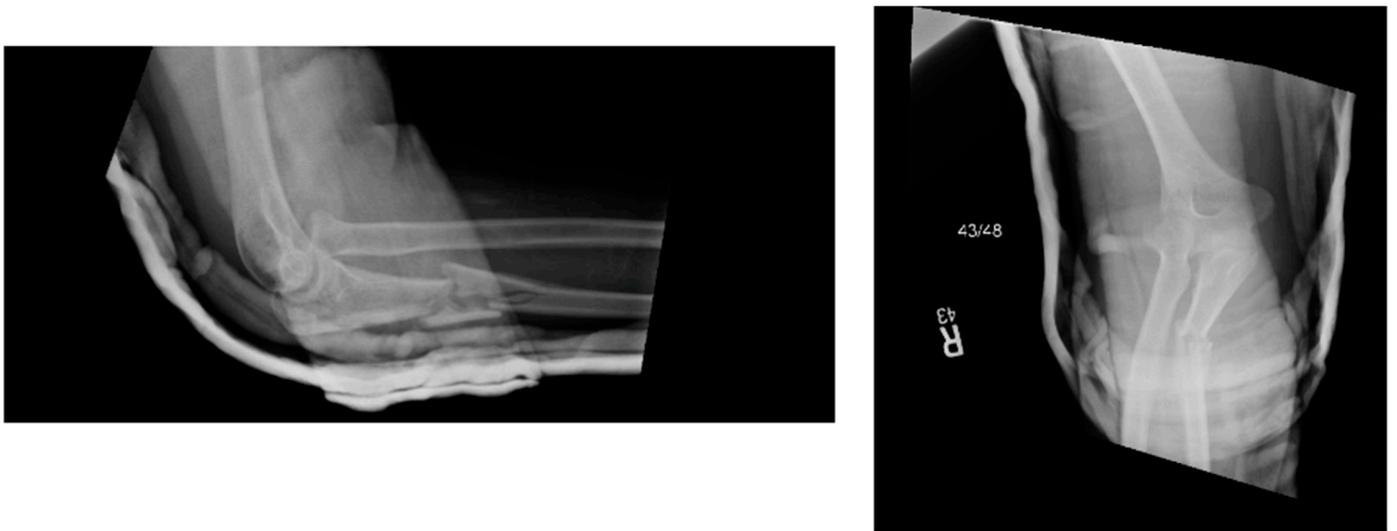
AP and lateral radiograph of right elbow demonstrating ulnar reduction after application of posterior arm splint.
